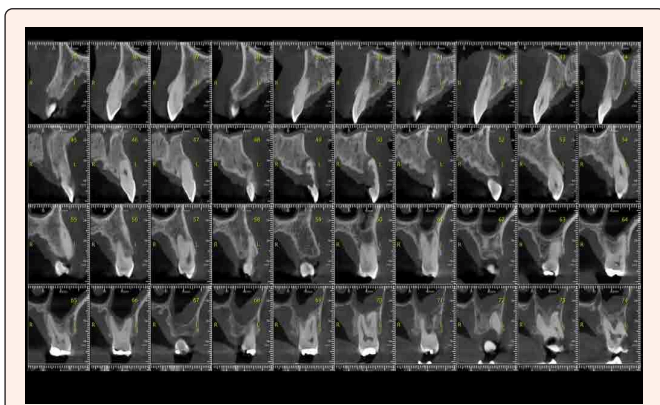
CBCT (Slices from affected bone).
